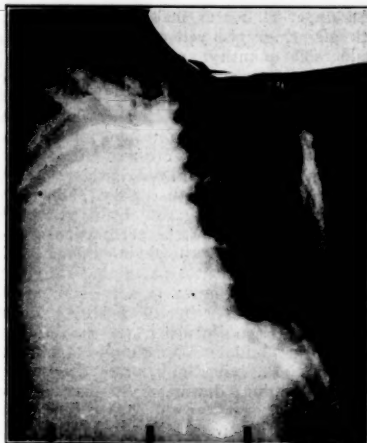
Roentgenogram of Case 1, Aug. 31, 1925. Complete density of right lung. Heart shadow and trachea pulled to right.
